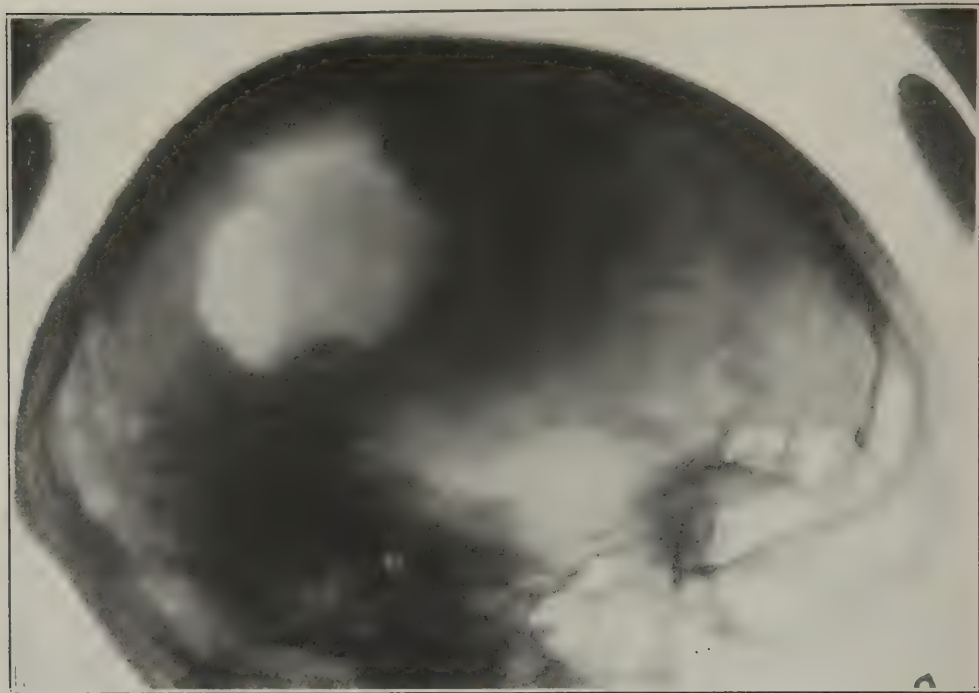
Posterior parietal defect. Roentgenogram before cranioplasty
